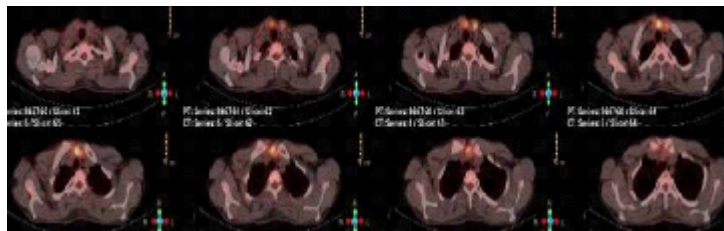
FDG-PET/CT showing erosive arthropathy of the right sternoclavicular joint (arrowhead)
